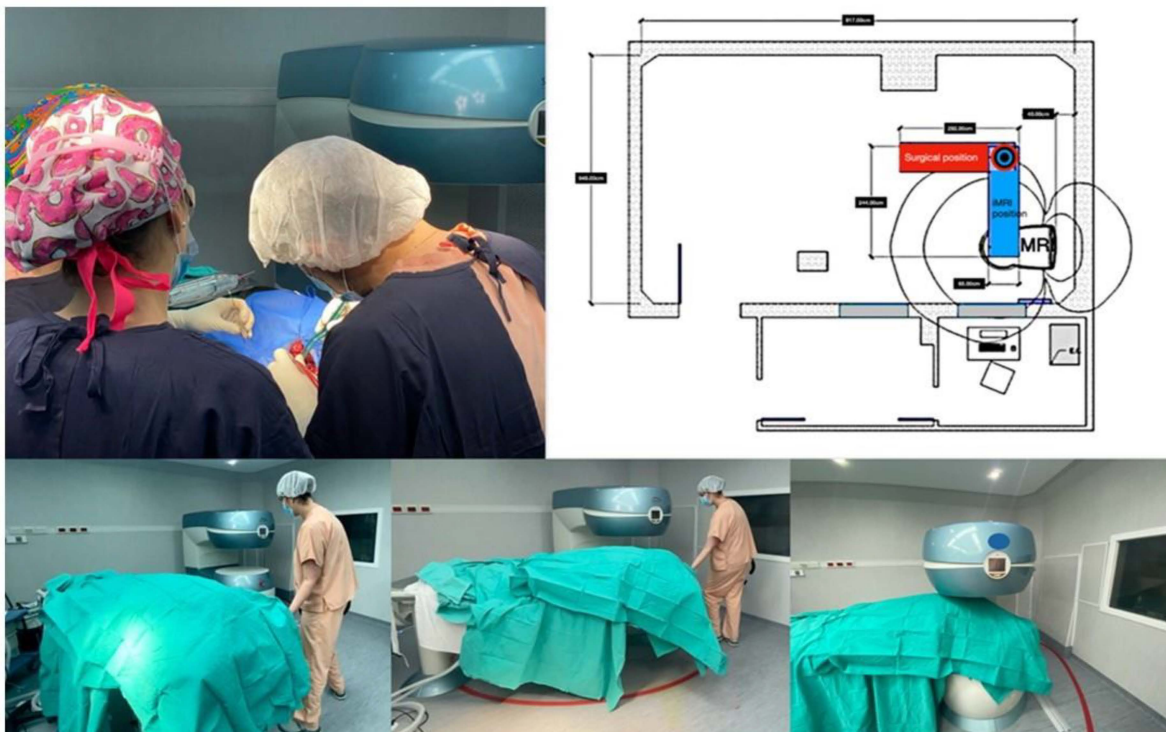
Operating theatre scheme. An open low-field (0.25 T) MRI system S-scan is installed inside a Faraday cage. The operating table has been set in the surgery position (red) to keep easy and quickly rotate it towards the inside of the magnet (blue) for the acquisition of intraoperative images (below).
